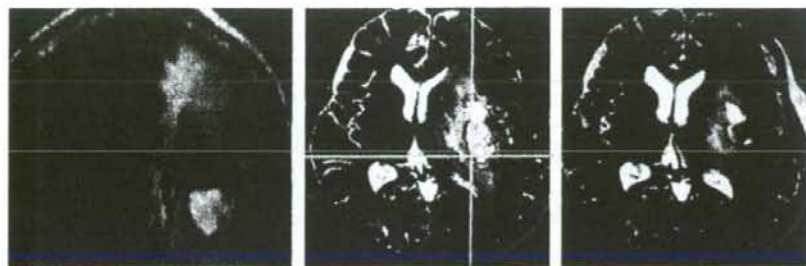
Patient No 2. Left: fibre-tracking of the pyramidal tracts (red lines) demonstrated disruption around a left fronto-insulo-temporo-parietal glioblastoma multiforme. Middle: during removal of the tumour, cortical stimuli did not elicit any motor evoked potentials (MEPs). Subcortical stimuli very close to the predicted pyramidal tracts (red) on neuronavigation (intersection of the yellow lines in an intraoperative navigation image), however, elicited MEPs of her affected right lower extremities, but not her right upper extremities. Right: Postoperative T2 weighted MRI demonstrated that the pyramidal tracts identified by fibre-tracking (red) were preserved.
